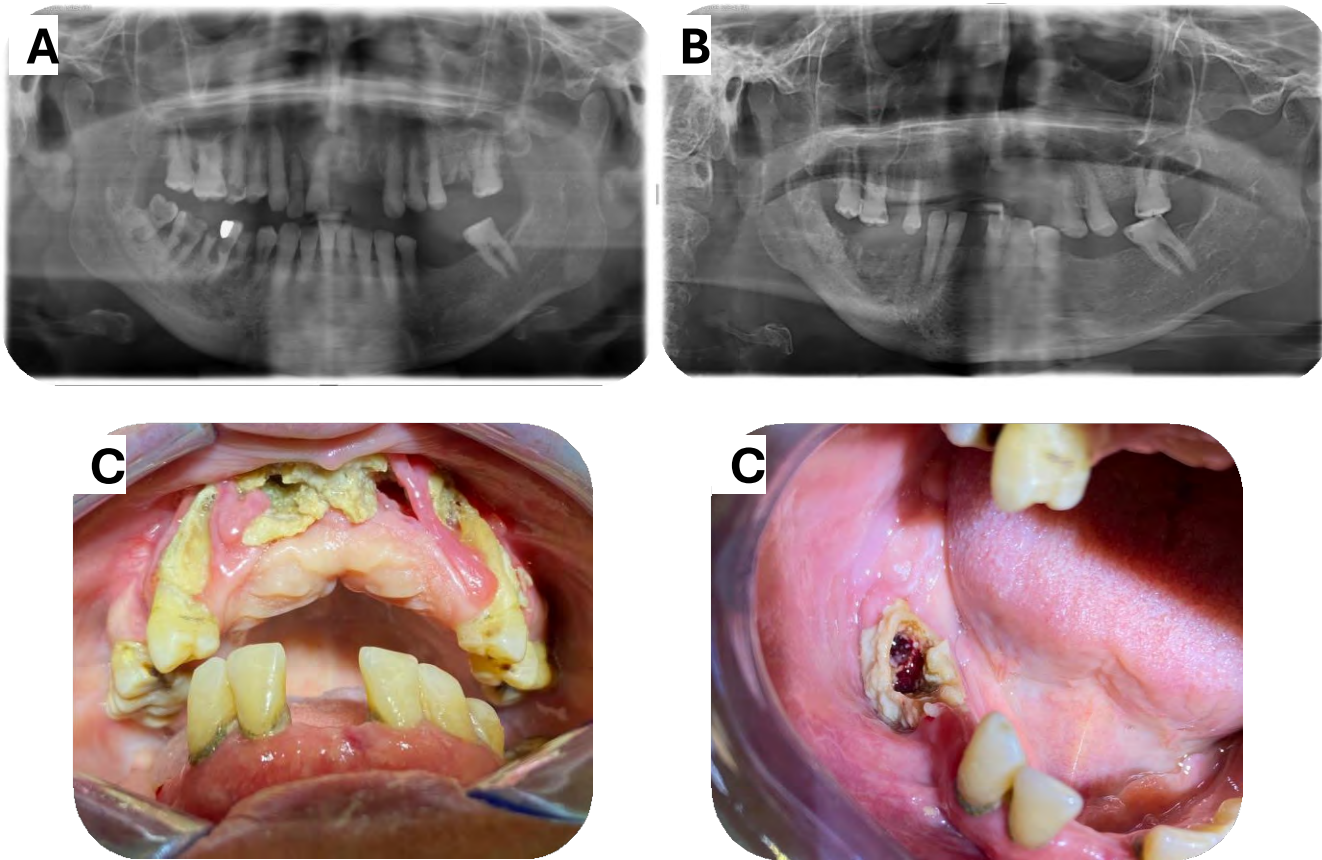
A: Preoperative radiographic view , B: Postoperative radiographic view , C: Intraoral view of necrotic bone exposure
